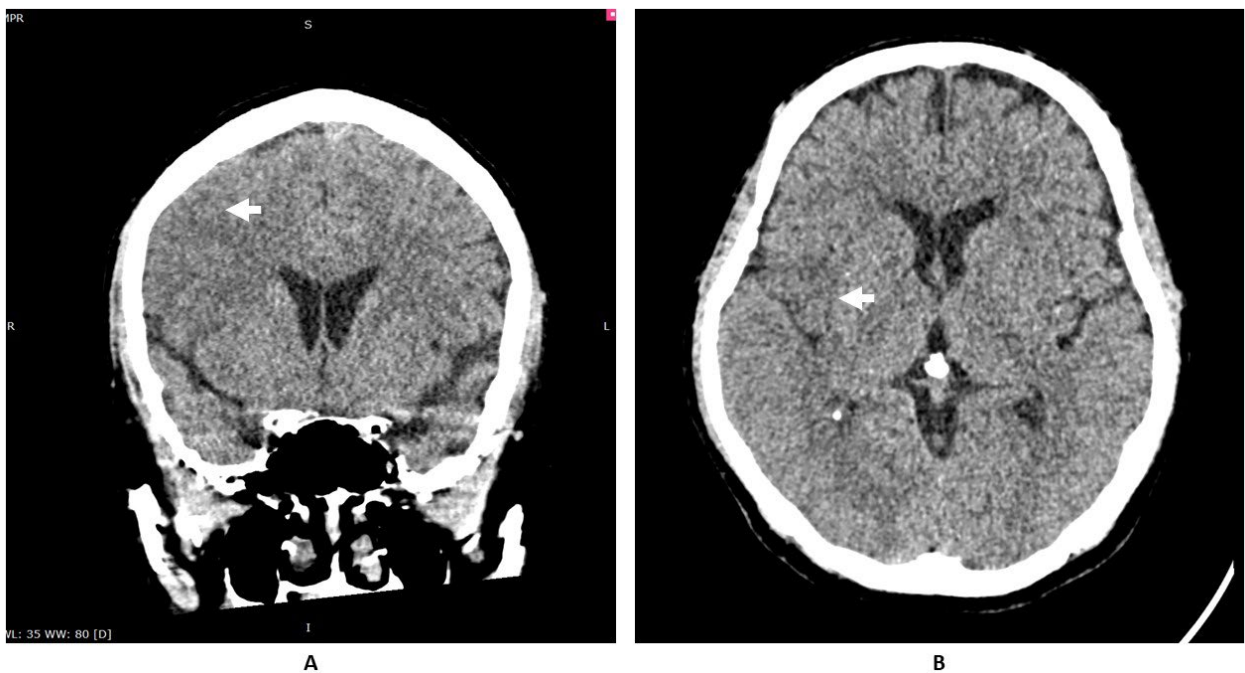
Head CT scan without contrast of patient in Case 1. (A) Sulcal effacement of the right parietal lobe (white arrow); (B) Sulcal effacement of the right insular lobe (white arrow).
